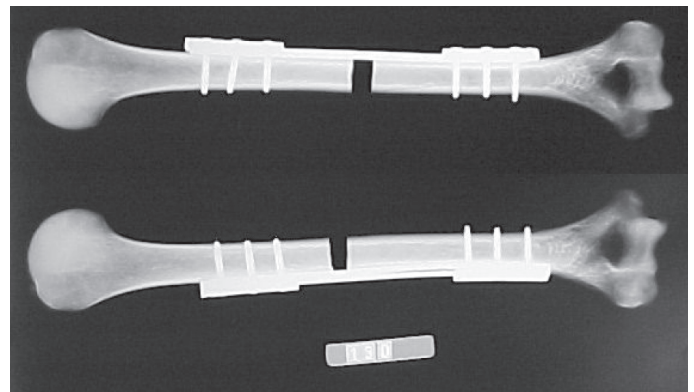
X-ray image of the SPS® assembly.
